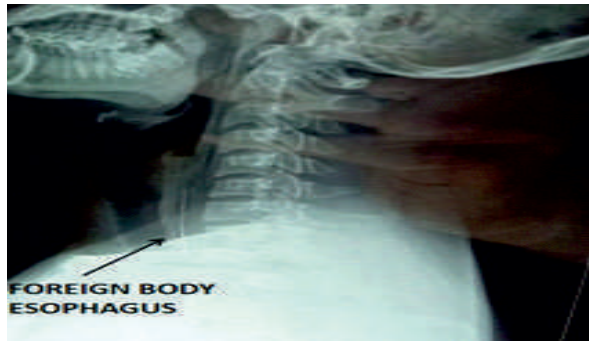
X-ray neck lateral view showing linear radio-opaque foreign body in the oesophagus at the level of C6-T2 vertebrae.
